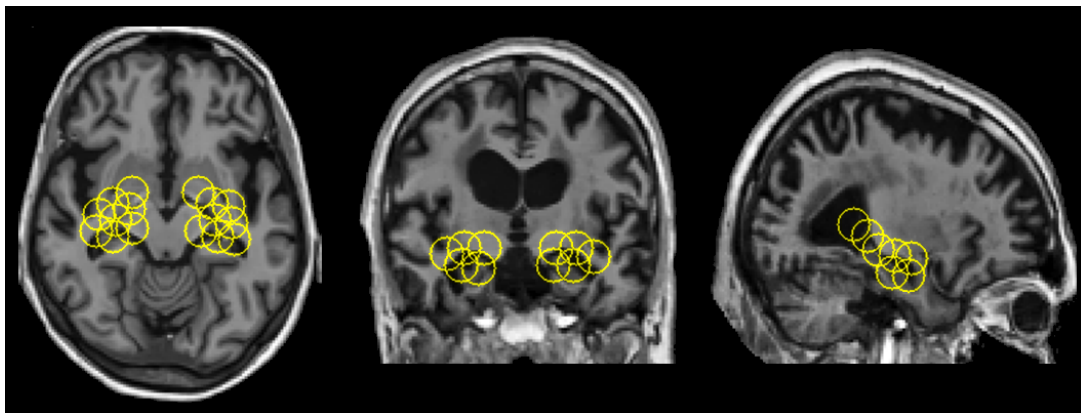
CHF's features placement on the hippocampus ROI (axial, coronal and sagittal planes) of an MRI slice of an ADNI subject
